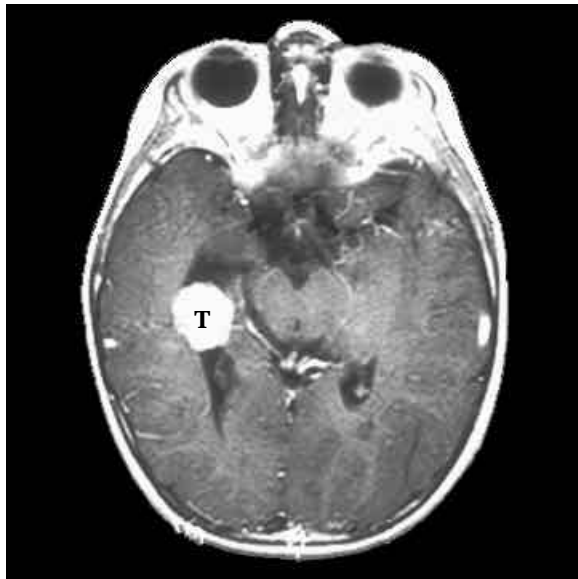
CHOROID PLEXUS PAPILLOMA T1 MRI. A papilloma is a nonspreading, benign epithelial tumor (T). Although not cancerous, these tumors can enlarge and compress surrounding tissues, impairing their normal function. It can also impair cerebrospinal fluid flow, producing hydrocephalus (see Figure 6).
